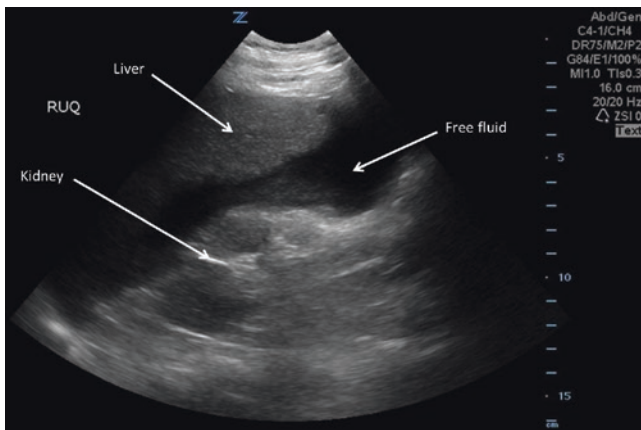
Ultrasound image of free fluid in the right upper quadrant. Peritoneal free fluid (anechoic) in the hepatorenal recess. Image courtesy of Pimpa Limphan-udom
